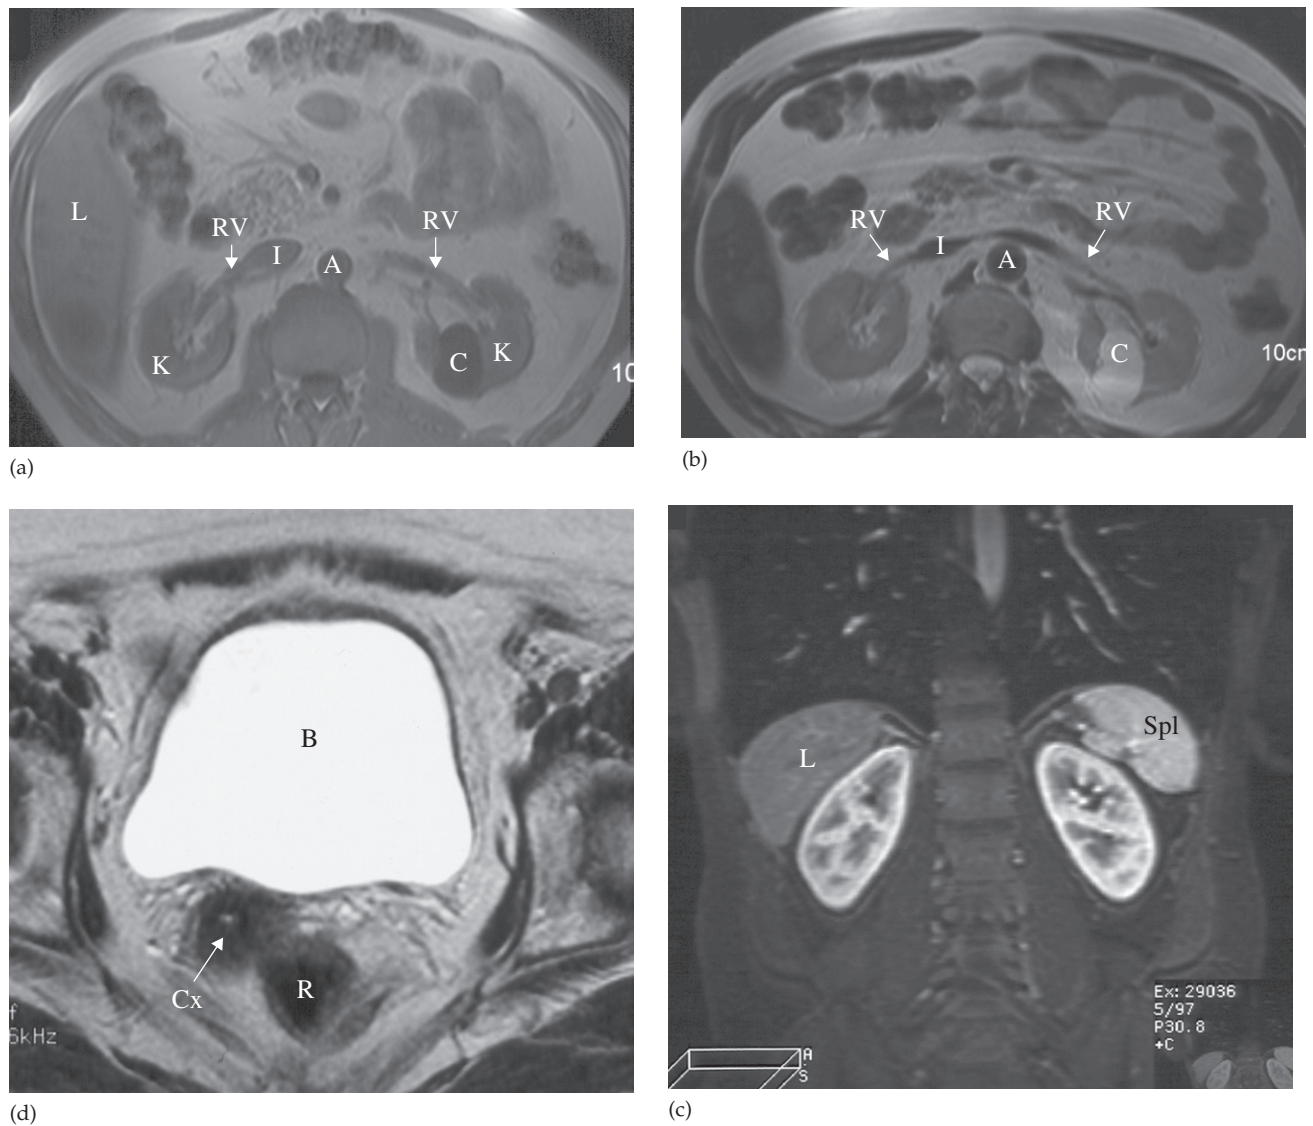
MRI of the kidneys. (a) T1-weighted and (b) T2-weighted images in the axial plane at the level of the renal hila. Note the simple cyst (C) in the left kidney, which returns a low signal on T1- and a high signal on T2-weighted images. (c) Coronal image of the kidneys, in a different patient, following intravenous gadolinium infusion. (d) Normal bladder (B) on a T2-weighted image. The bladder wall is thin and smooth. A, aorta; Cx, cervix; I, inferior vena cava; K, kidney; L, liver; R, rectum; RV, renal vein; Spl, spleen.
